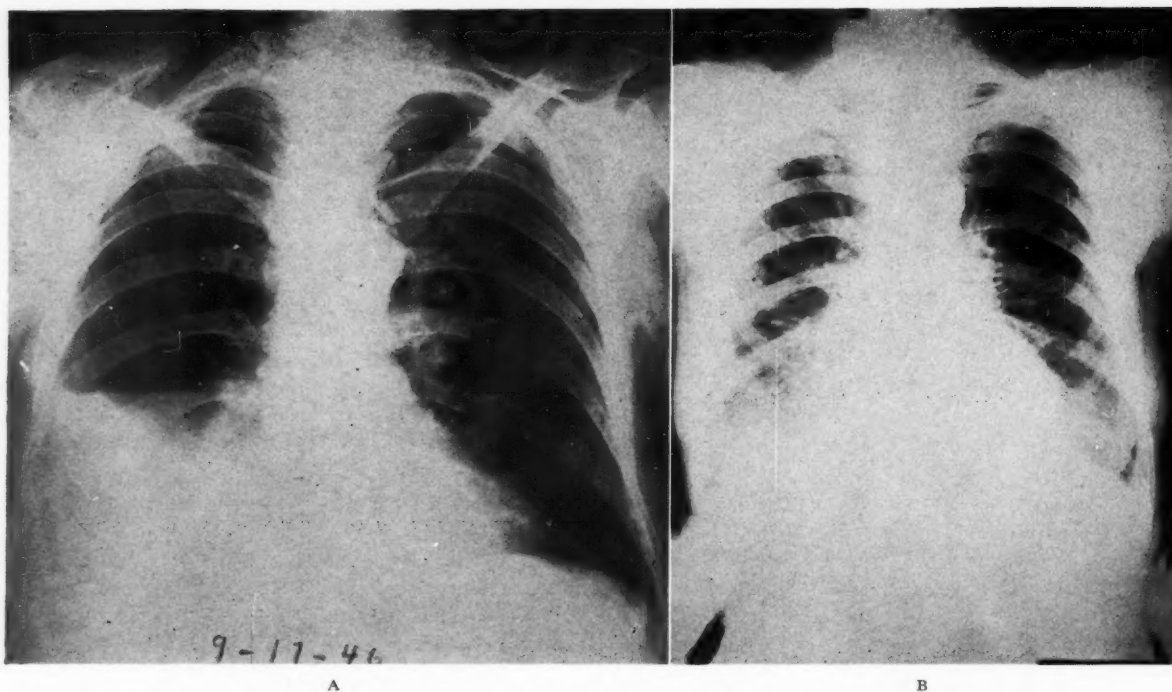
X-rays of the chest of Case II. A, before the first thoracentesis; B, fourteen weeks postoperatively.
